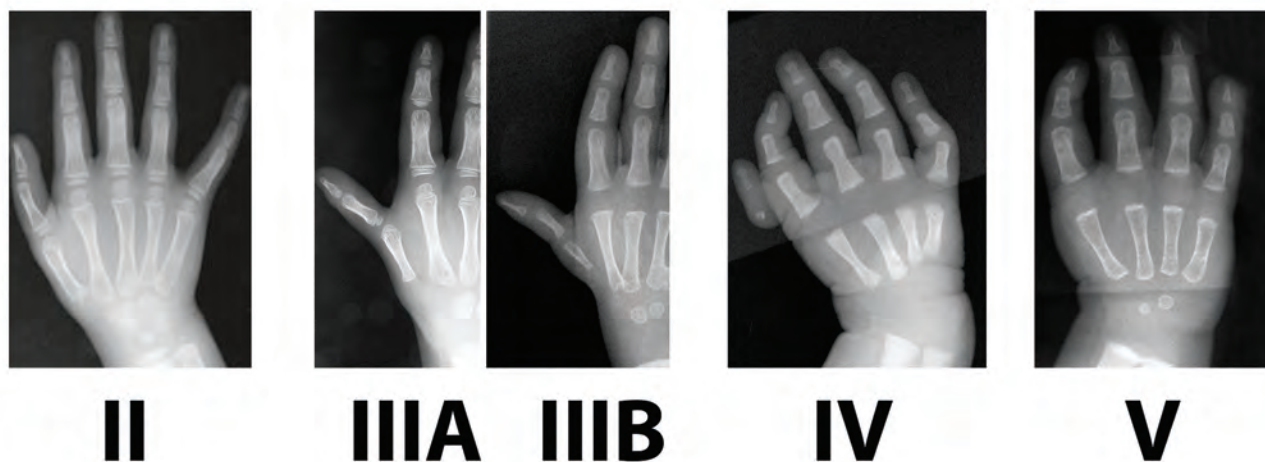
Radiographical classification of thumb hypoplasia. Type I hypoplasia, the mildest severity, is not shown. The main distinguishing feature between type IIIA and IIIB hypoplasia is the presence of a functional carpometacarpal joint.
